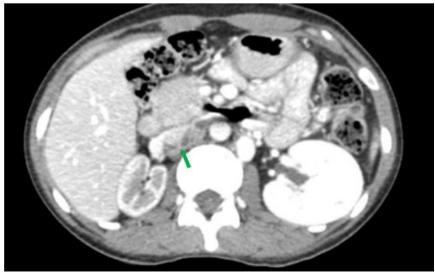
CT-Scan of abdomen, axial view. Adenopathic conglomerates around the abdominal aorta and right renal artery, green arrow.
